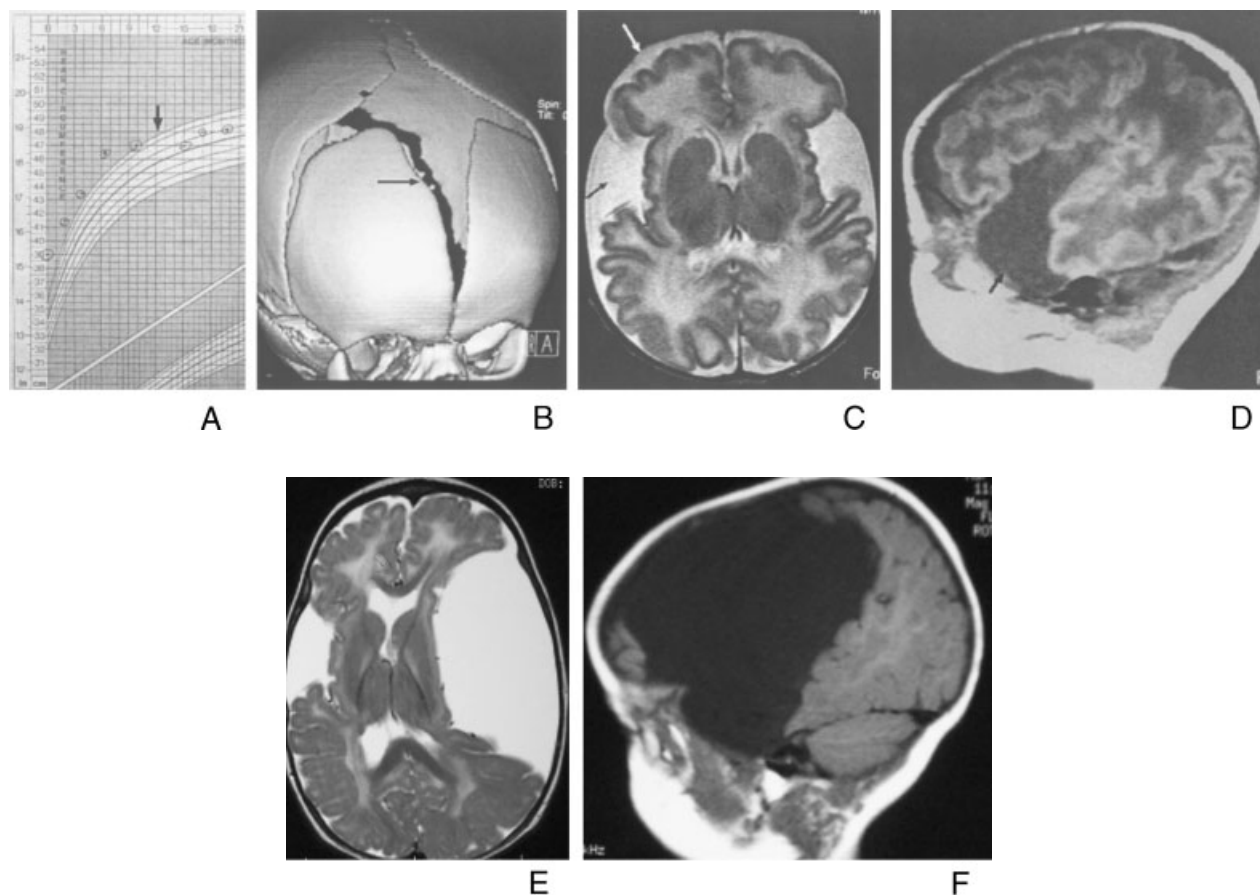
Micrencephalic macrocephaly. Seventy percent of our patients are born with an occipitofrontal head circumference of >95th percentile, and fontanelles are often bulging in asymptomatic neonates. A: Head growth generally increases on a stable trajectory and then may decelerate between 6 and 8 months of age, preceding development of acute striatal necrosis (arrow). B: Cranial CT scan with 3D reconstruction shows widely split cranial sutures (arrow) and fontanelles (arrowhead) of communicating hydrocephalus in a neonate. CSF from these infants may have a mildly elevated opening pressure, increased protein level, and high pH. Red blood cells and xanthochromia may also be present. C (axial): Cranial MRI of an asymptomatic newborn shows mild enlargement of the cerebral ventricles and expansion of the fluid spaces around the brain stem and over the cerebral convexities. Fluid collections are most evident over the frontal lobe (white arrow) and in the middle cranial fossae (black arrows); the underlying frontal, anterior temporal, and opercular cortices are hypoplastic. In contrast, the basal ganglia appear normal. D: With advancing age, the fluid space around the brain may increase, in part a reflection of poor brain growth and a hypoplastic intermediate fiber zone. E (coronal) and F (sagittal): In three patients, true arachnoid cysts developed in the middle cranial fossae and were devoid of radiologically evident bridging veins. This massive left-sided cyst was present at age 10 months in the patient depicted as a neonate in panel C. It was found incidentally, it was not surgically decompressed, and he remained completely asymptomatic. Note T2 hypersignal of terminal zone white matter and the internal pallidi.
